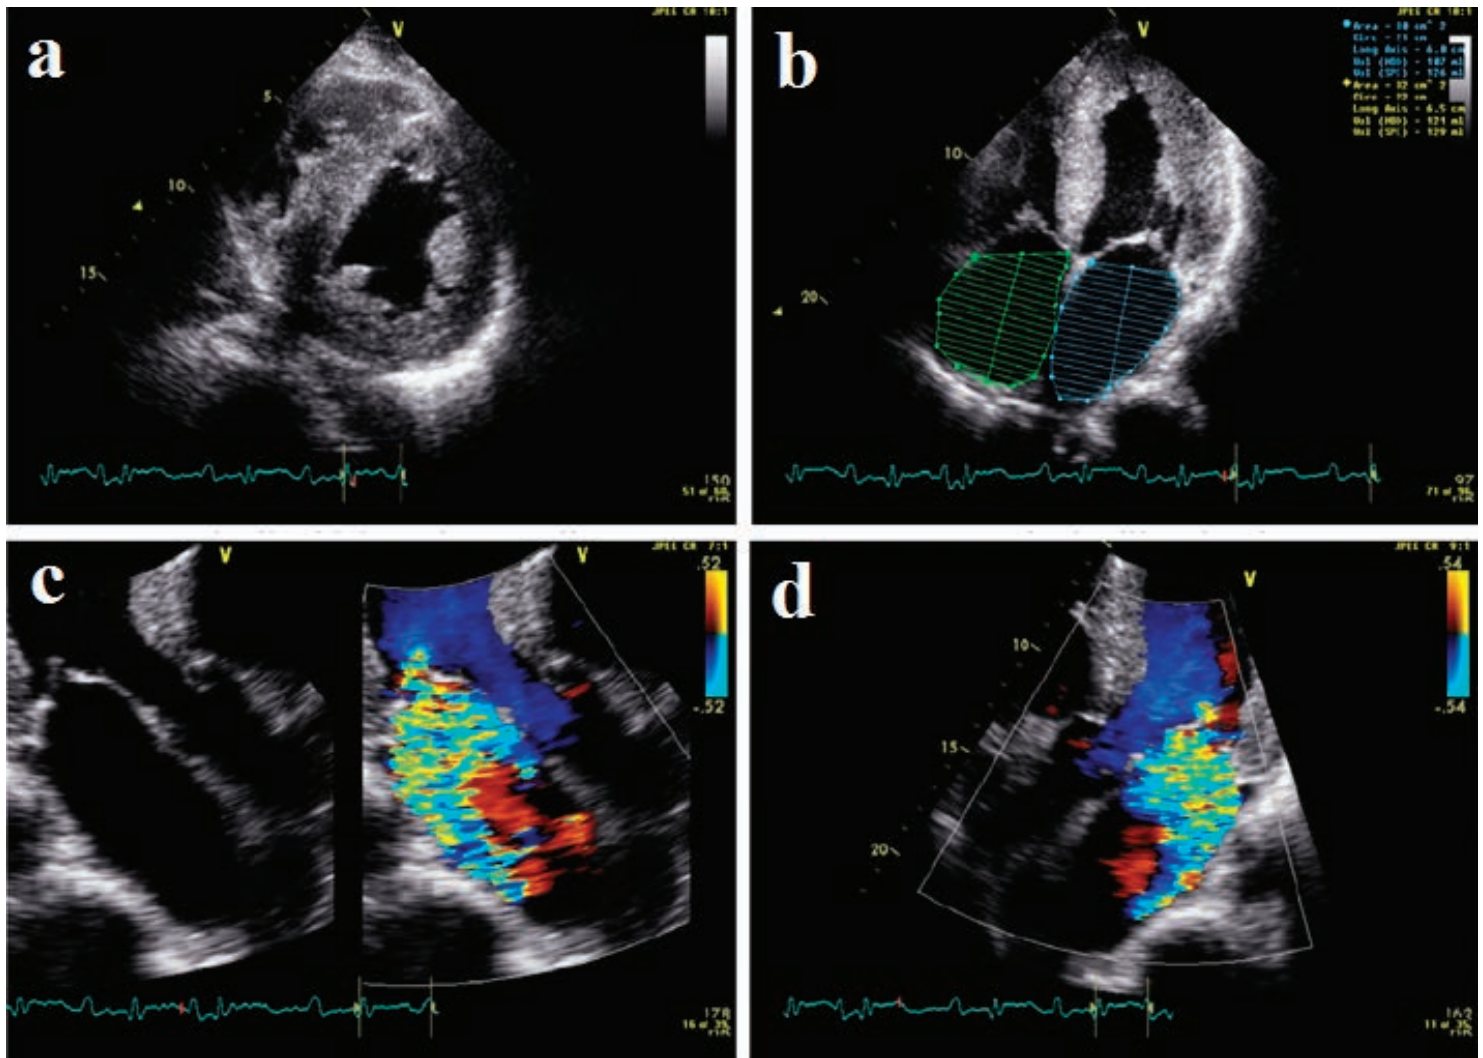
Transthoracic echocardiogram showing the following: (a) severe concentric left ventricular hypertrophy with moderately dilated left ventricular size (93 ml/m²); (b) massively dilated atria; and (c, d) moderate to severe mitral regurgitation.
